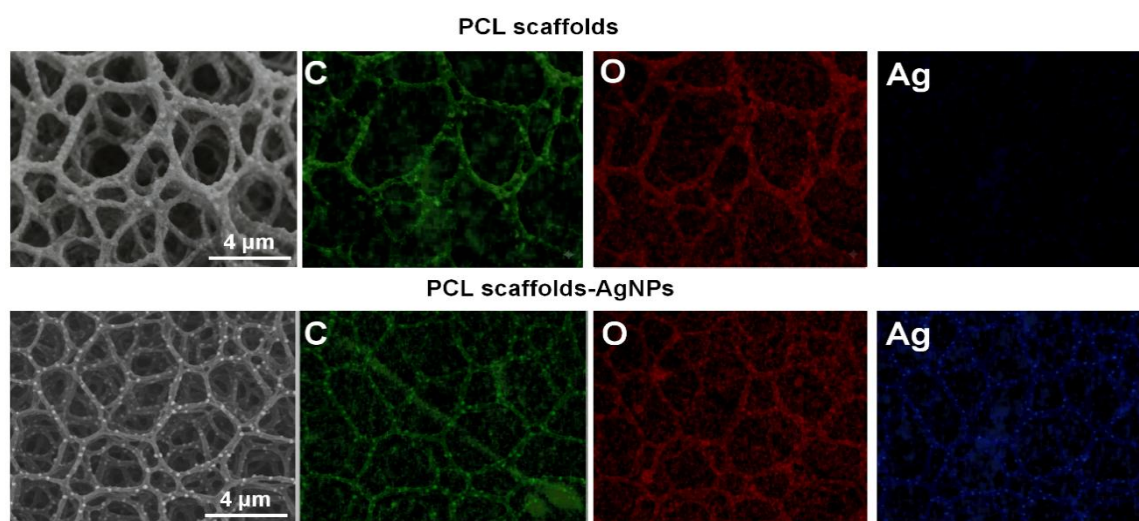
Secondary electron SEM image of the scaffold cross-section and Carbon (C), Oxygen (O), and Silver (Ag) X-ray signals over the same area
